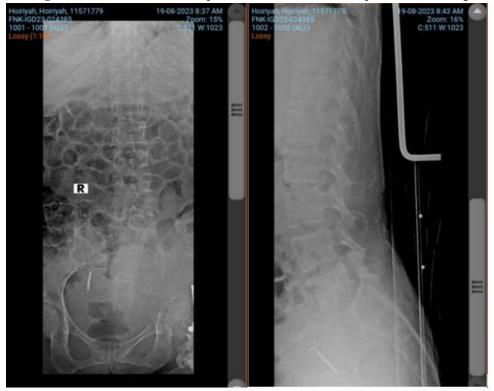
X-ray photo of AP/lateral lumbosacral patient
